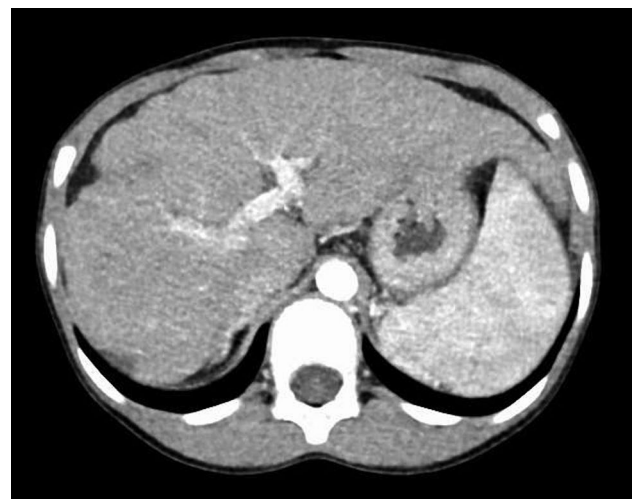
Contrast-enhanced computed tomography shows hepatosplenomegaly
